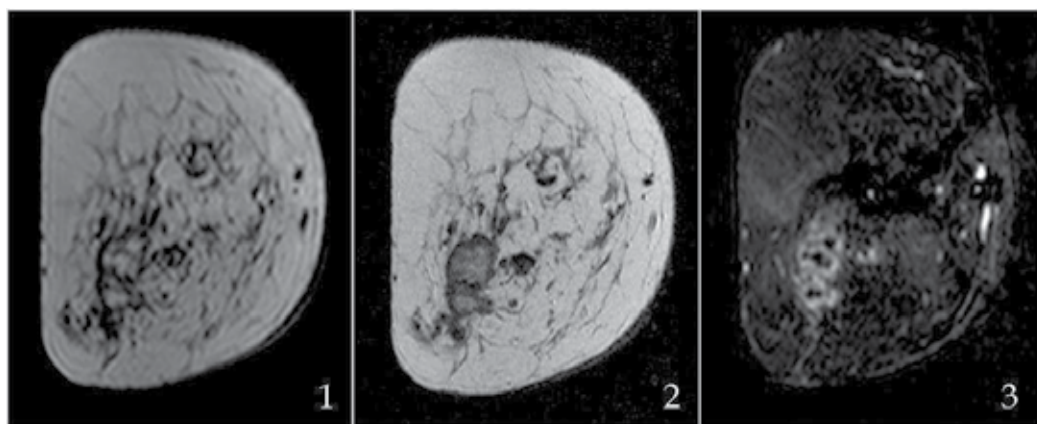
Right breast three years after surgery for infiltrating ductal carcinoma. MRI shows an irregular mass with hyperintense foci in T1-weighted sequences (1) that are slightly hypointense in T2-weighted sequences (2); the mass has irregular peripheral enhancement after intravenous contrast administration (3). In this clinical context, it is imperative to rule out relapse of the tumor. Vacuum-assisted biopsy: fat necrosis.
